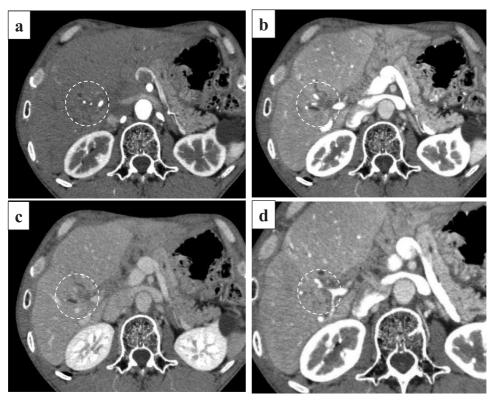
Abdominal dynamic CT showing mass formations along the hilar bile duct. Marginally enhanced masses were observed during the arterial (a) and portal (b,d) phases, but were attenuated during the venous phase (c). Hilar lesions suggested invasion of the posterior segmental branch of the hepatic artery (a) and the right primary branch of the portal vein (b), but the hepatic vein was intact (c).
